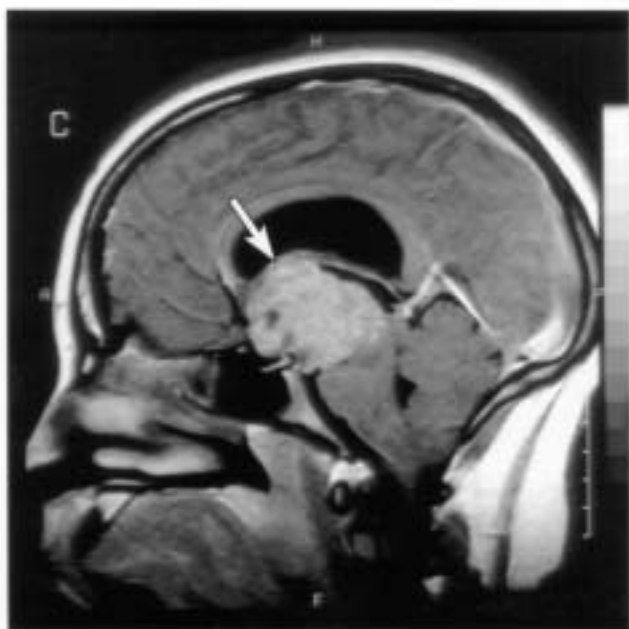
The MRI for patient #1 is shown. The sagittal, T1-weighted, contrast enhanced magnetic resonance image demonstrates a large suprasellar mass (arrow), which on pathology was diagnosed as a germinoma. The tumor displaces the mid-brain and upper portion of the pons. Mild obstructive hydrocephalus of the lateral ventricles is evident, with posterior and superior displacement of the third ventricle and a normal sized fourth ventricle.
